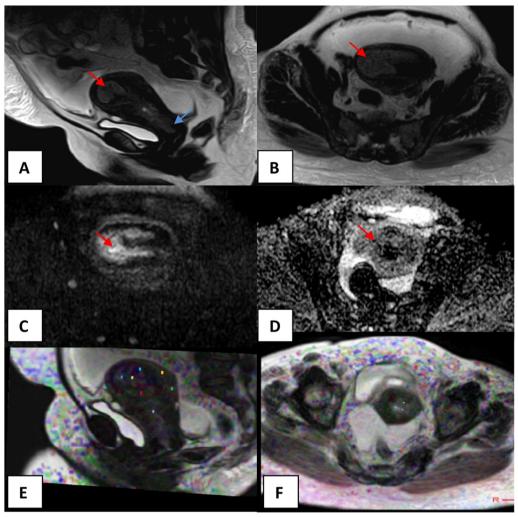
A 54-year-old postmenopausal female presented by abnormal vaginal bleeding. A, B *Sagittal and axial T2 WIs* irregular endometrial soft-tissue mass with ill-defined margins displaying intermediate SI (red arrow). The mass distends and fills the endometrial cavity with myometrial thinning. The mass also extends to the cervix (blue arrow). C *Axial DWI with b value of 1000 s/mm*² high SI of the endometrial soft-tissue mass (red arrow). D *Axial DW-ADC map image* low signal intensity of the endometrial soft-tissue mass(red arrow). Mean DW-ADC value of the mass = 0.839×10^{-3} mm²/s. Mean DW-ADC values at areas of intact and infiltrated myometrium = 1.073 and 0.853×10^{-3} mm²/s, respectively. E, F *Sagittal and axial DTI map images* values of DT-FA and DT-MD in multiple ROI. Mean DT-FA and DT-MD values of the endometrial mass = 0.240 and 0.711×10^{-3} mm²/s, respectively. Mean DT-FA and DT-MD values at areas of infiltrated myometrium = 0.215 and 0.683×10^{-3} mm²/s, respectively. Mean DT-FA and DT-MD values at areas of intact myometrium = 0.423 and 1.069×10^{-3} mm²/s, respectively. *Diagnosis* Pathologically proved endometrioid adenocarcinomaG3
